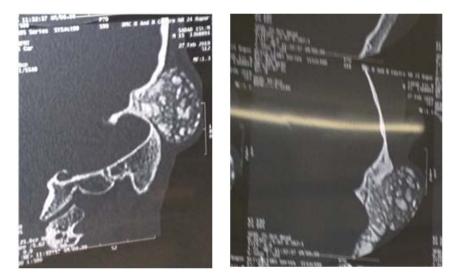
High Resolution Computed Tomography (HRCT) Temporal Bone
